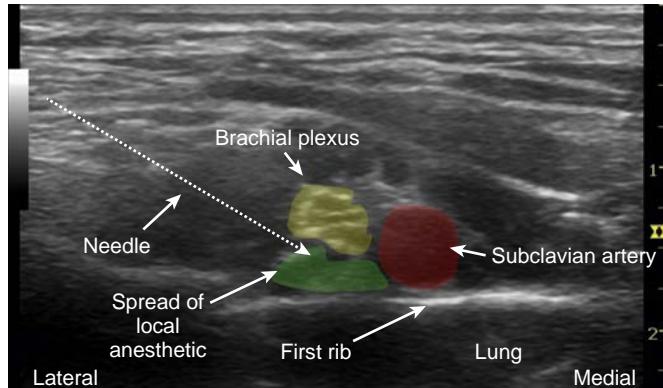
Ultrasound supraclavicular block imaging.
